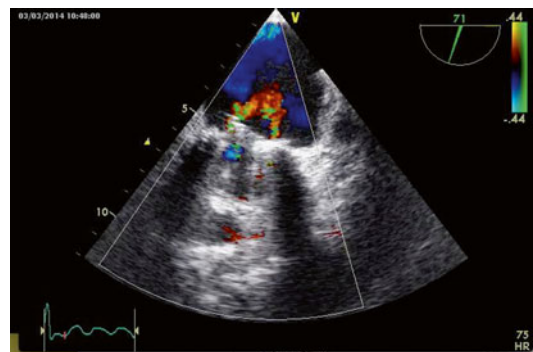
Transesophageal echocardiography showing two physiologic jets due to lavage volume
